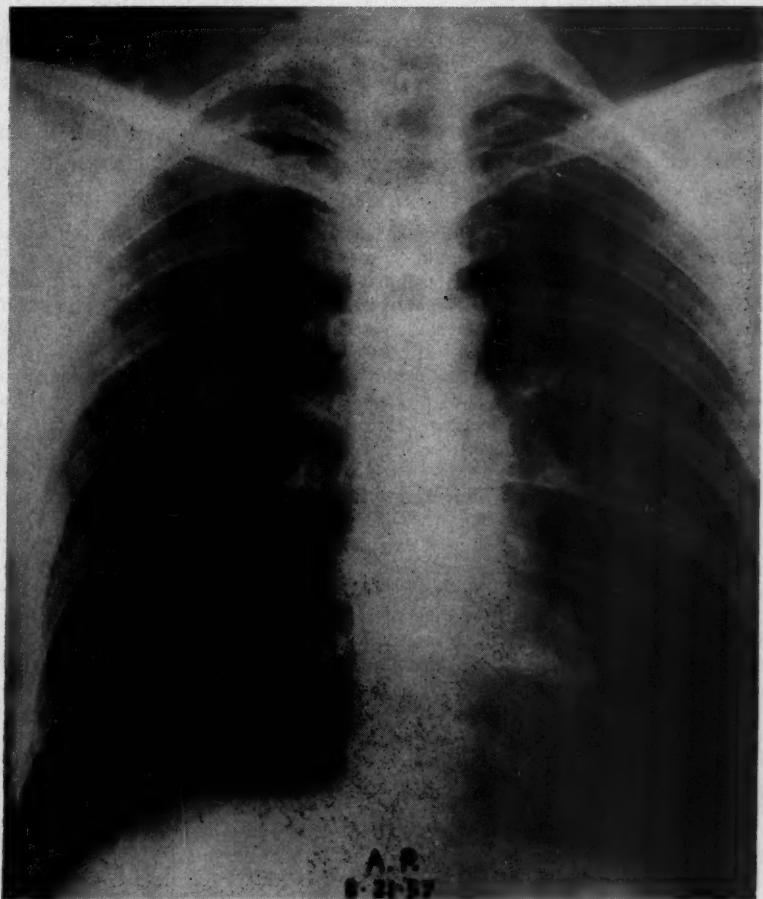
Chest x-ray of case 12 one year after onset, showing almost complete clearing of lesions.
